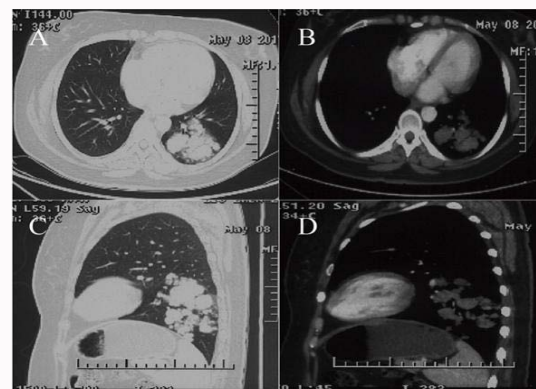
Computed tomography scans of chest. There were multiple high-density nodules with different sizes which subsequently exhibited intense enhancement which located in the lower lobe of the left lung.
